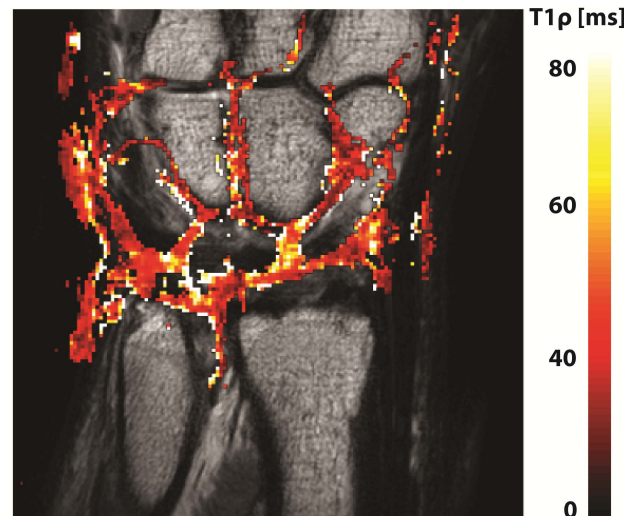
Quantitative $T_{1\rho}$ image superimposed on a high resolution T_2 weighted MRI of the human wrist, coronal view of a right. The ultra high resolution at 0.5 mm provides detailed spatial information of $T_{1\rho}$ required for the thin cartilage within the wrist.
